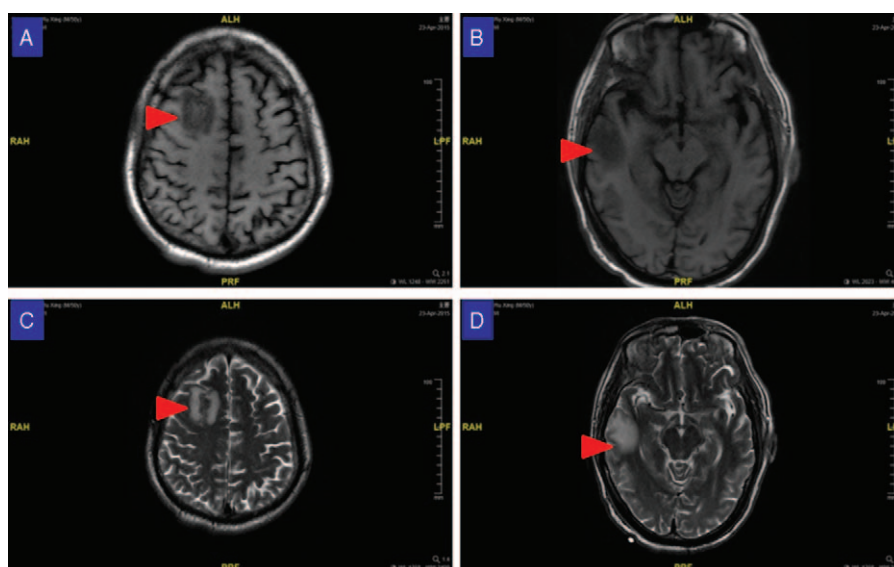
Axial T1-weighted MR image showing decreased signal intensity (A, B). T2-weighted MR image showing increased signal intensity in the lesions. MR = magnetic resonance.
